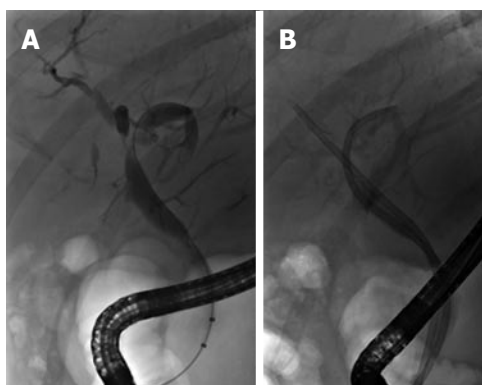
Anastomotic and nonanastomotic biliary strictures in a liver transplantation patient. A: Anastomotic biliary stricture and hilar nonanastomotic biliary strictures are present; B: Radiographic image taken immediately following placement of a 10-Fr 15 cm Cotton-Leung (Cook Medical) and a 10-Fr 22 cm (cut down to 16 cm) Jolithin (Cook Medical) plastic biliary stent.
